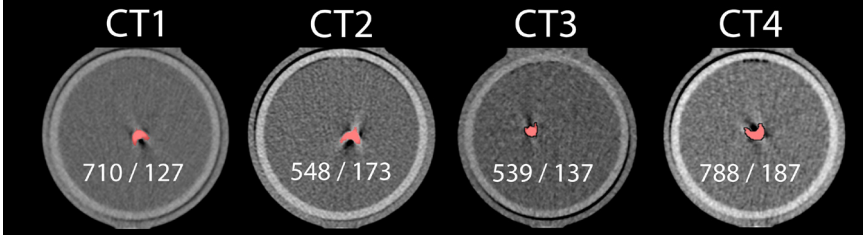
Example images for all CT systems of the high mass (157 mg) calcification at >75 bpm. Agatston / mass scores are given for each CT system
